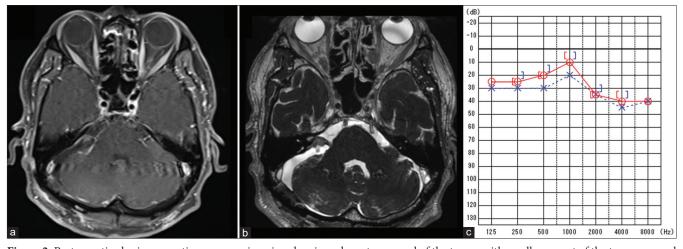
Postoperative brain magnetic resonance imaging showing adequate removal of the tumor with small remnant of the tumor around the facial-vestibulocochlear nerve complex (a and b). Postoperative pure-tone audiometry showing significant improvement in the right ear (c).
